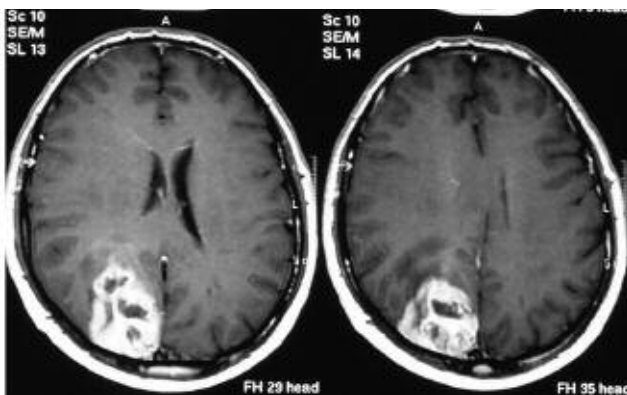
T1-weighted axial MRI sequences with contrast enhancement showing the glioblastoma in the right occipital lobe before the surgery.
